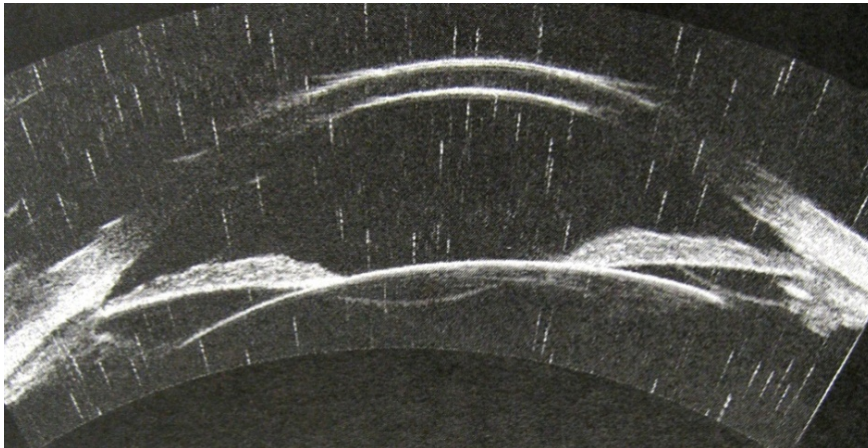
B-Scan anterior segment profile from Artemis 2 VHF ultrasound system (Pinero, Belen Plaza and Alio, 2008).
